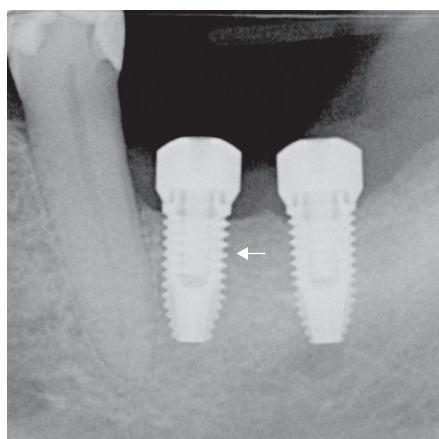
Proper parallel technique: good position of the film and correct orientation of the X-ray. Note the accurate appearance of the threads of the implant.
